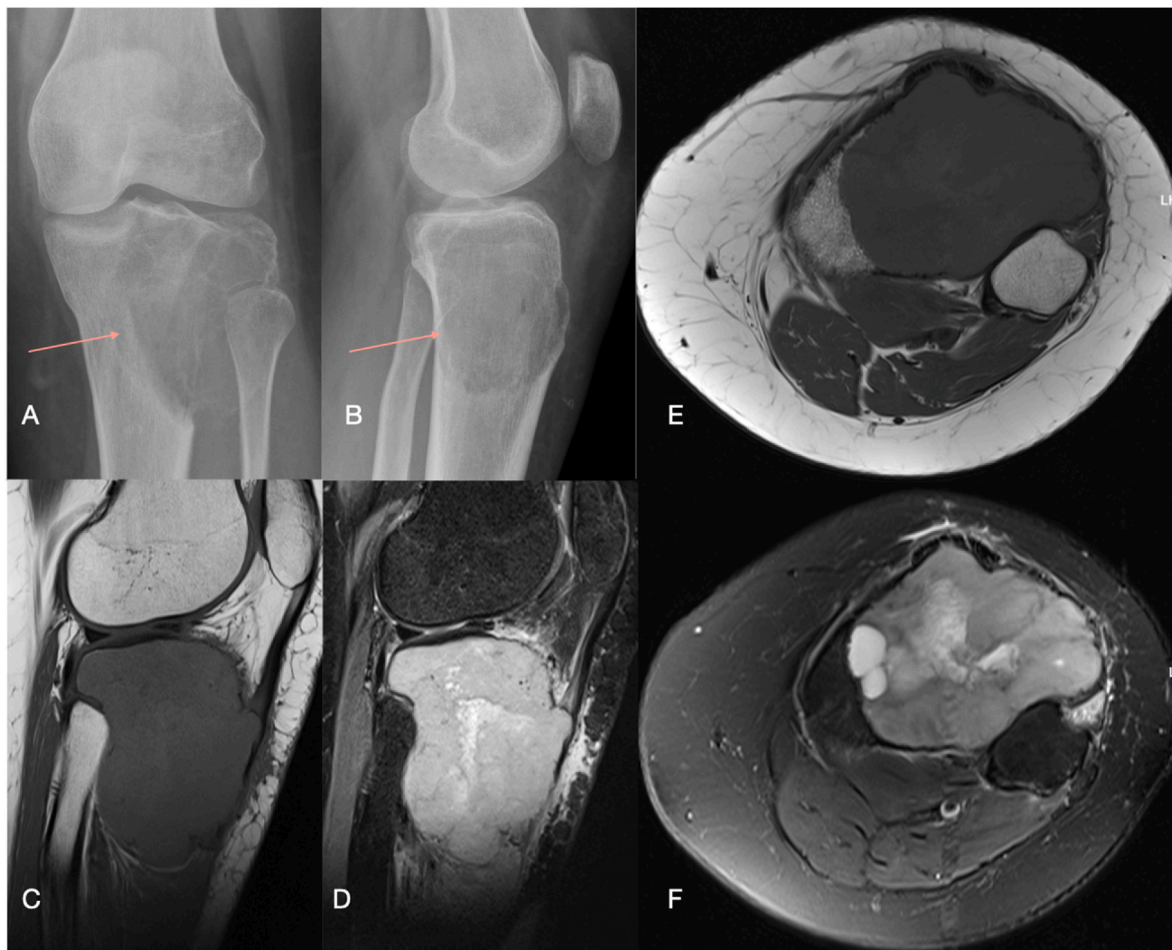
A–F: (A) Frontal radiograph showing a well-circumscribed, expansile and osteolytic lesion in the left proximal tibia with extension to the subarticular bone plate in keeping with GCTB; (B) Lateral radiograph further characterising the expansile osteolytic lesion; (C) T1-weighted sagittal and (E) axial MR images showing homogenous intermediate signal expansile mass in the proximal tibia with subarticular extension; (D) Short tau inversion recovery (STIR) sagittal and (F) axial images showing heterogeneous intermediate-high signal. No extraosseous component evident.
